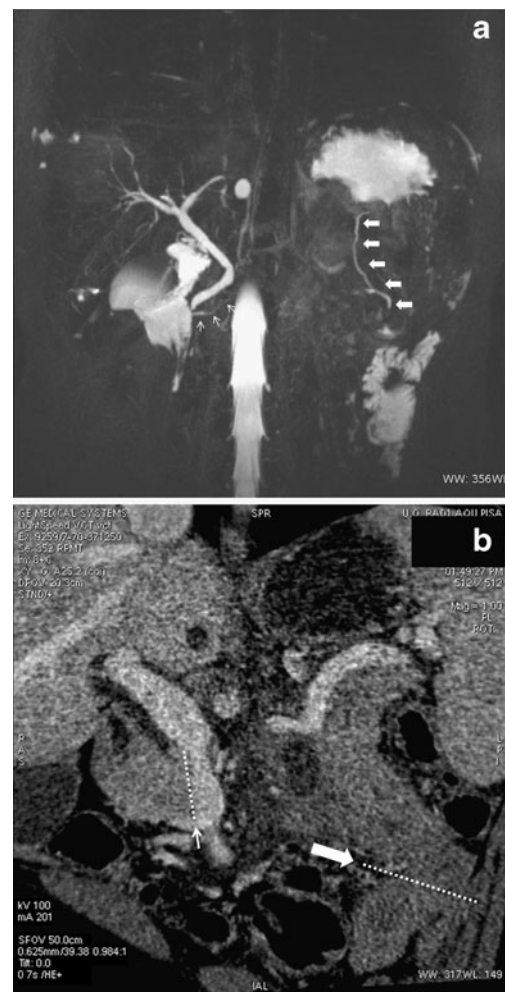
a MIP reconstruction in the coronal plane from MRCP sequences showing the near vertical orientation of the main pancreatic duct in the distal pancreatic stump (*large arrows*). *Thin arrows* point at main pancreatic duct in the cephalic remnant. b MPR reconstruction in the coronal plane obtained from the venous phase of multislice computed tomography scan. *Large arrow* indicates the cut edge of the distal pancreatic remnant; *thin arrow* points at the cut end of the cephalic pancreatic remnant
